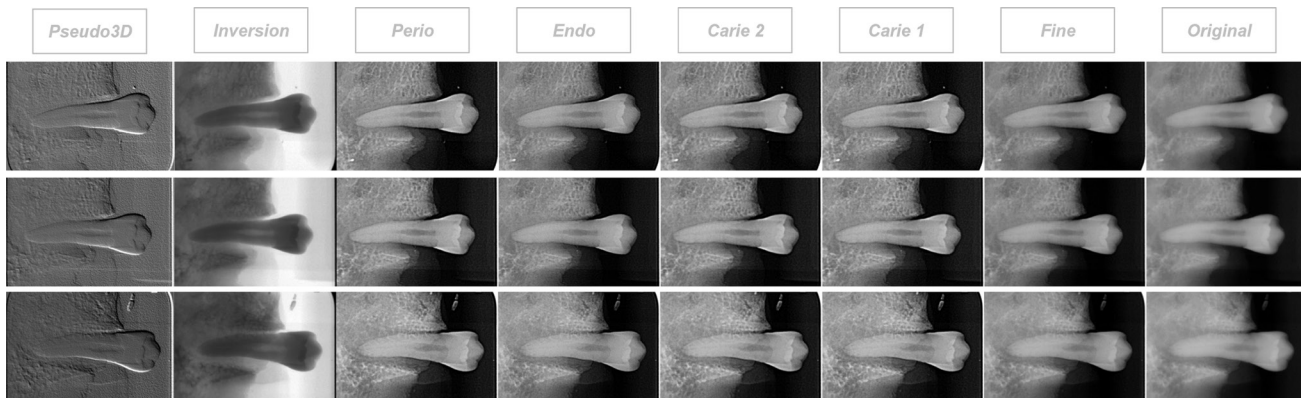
Radiographic images; original (unfiltered) and with post-processing filters, showing a tooth with IRR.
